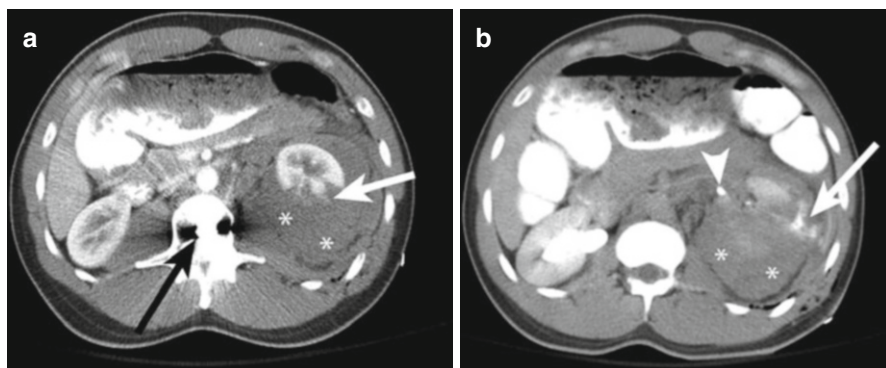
A 58 year-old male sustained a gunshot wound to the left flank. (a) Contrast-enhanced CT shows laceration (*white arrow*) of the left kidney and complex fluid (*asterisks*) in the perinephric space. A bullet fragment (*black arrow*) is lodged in the vertebral body. (b) Excretory phase image shows contrast in the ureter (*arrowhead*) and extravasating (*arrow*) into the complex perinephric fluid (*asterisks*) due to disruption of the collecting system
